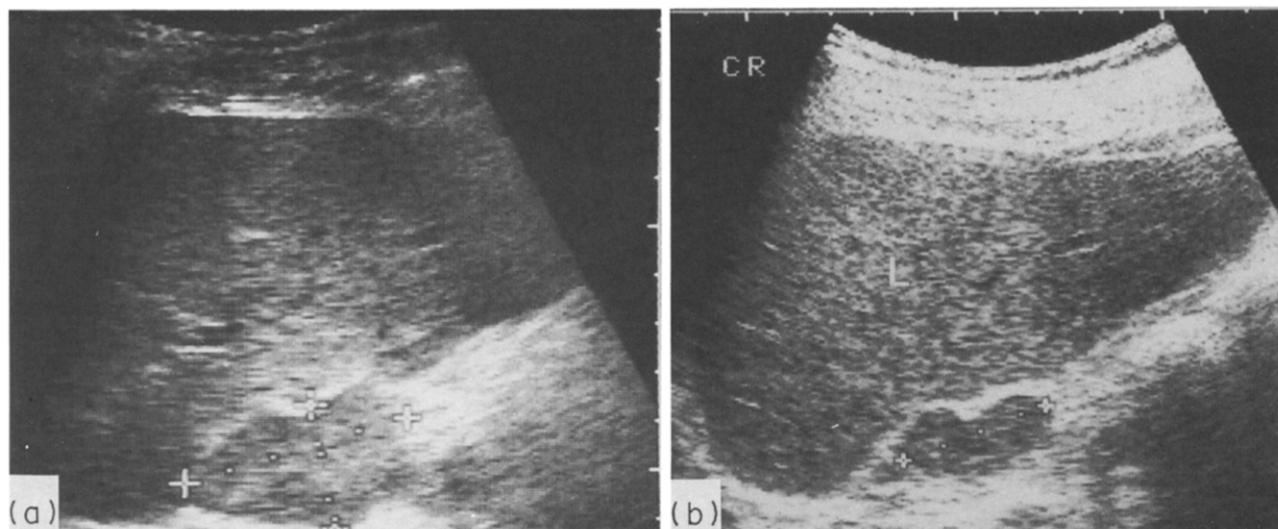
Initial sonogram (a) in a patient with lung cancer shows irregular delineated adrenal lesion. Follow-up examination after the first cycle of chemotherapy (b) revealed tumour regression. l = liver.
